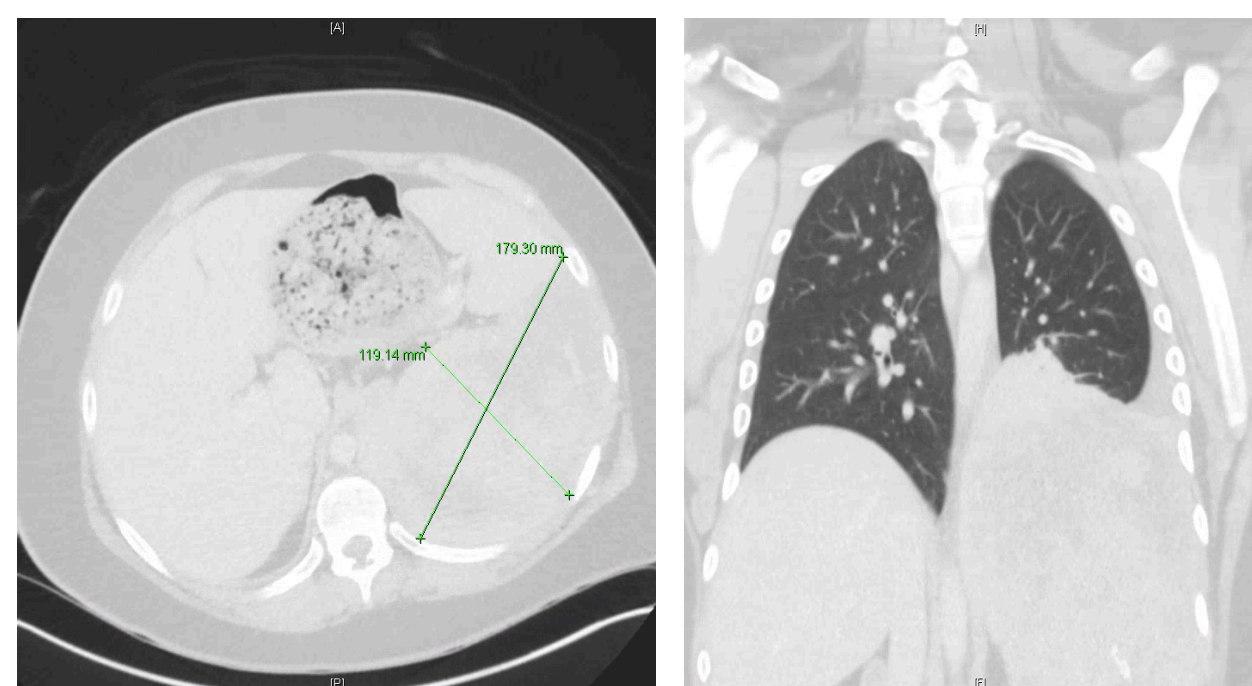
CT chest with contrast. Large LUQ mass causing atelectasis.
